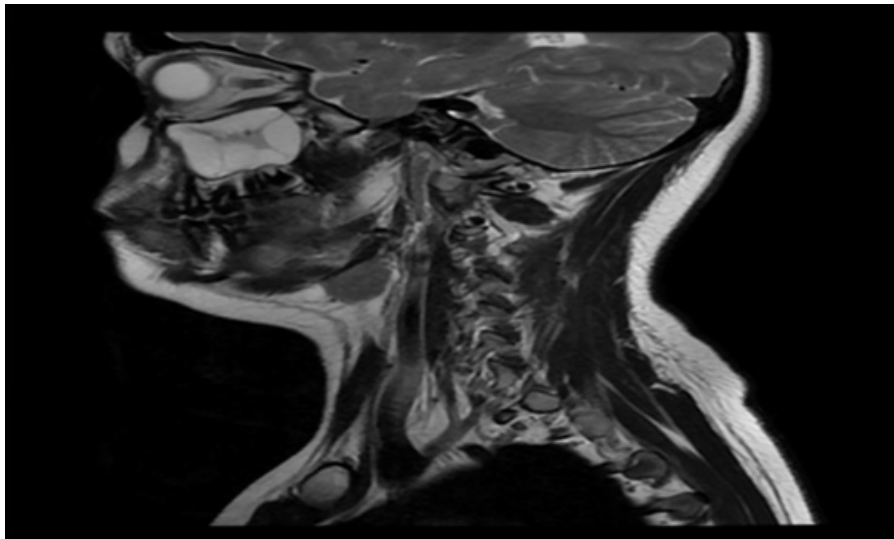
Magnetic resonance imaging (MRI) done shows lesions in the Cervical part (Sag T2 frFSE).
